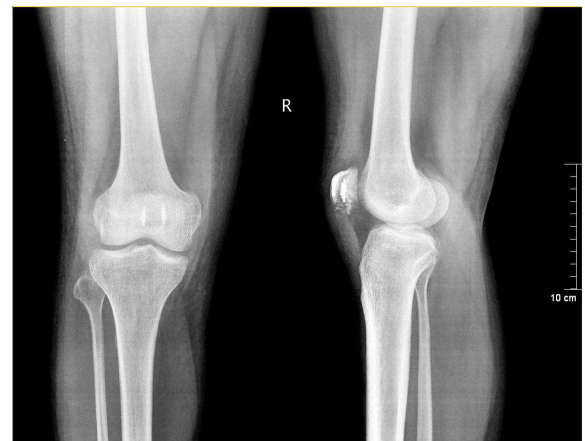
AP and lateral radiographs depicting the repair of patella to the patellar ligament with anchors
